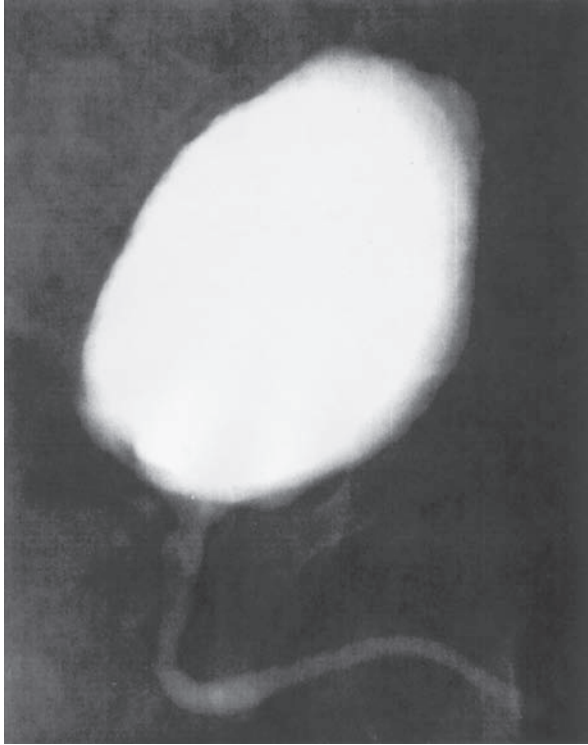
Radiographic urethrogram of a patient with a reconstructed urethra using a collagen matrix shows maintenance of a wide caliber without any evidence of stricture.
